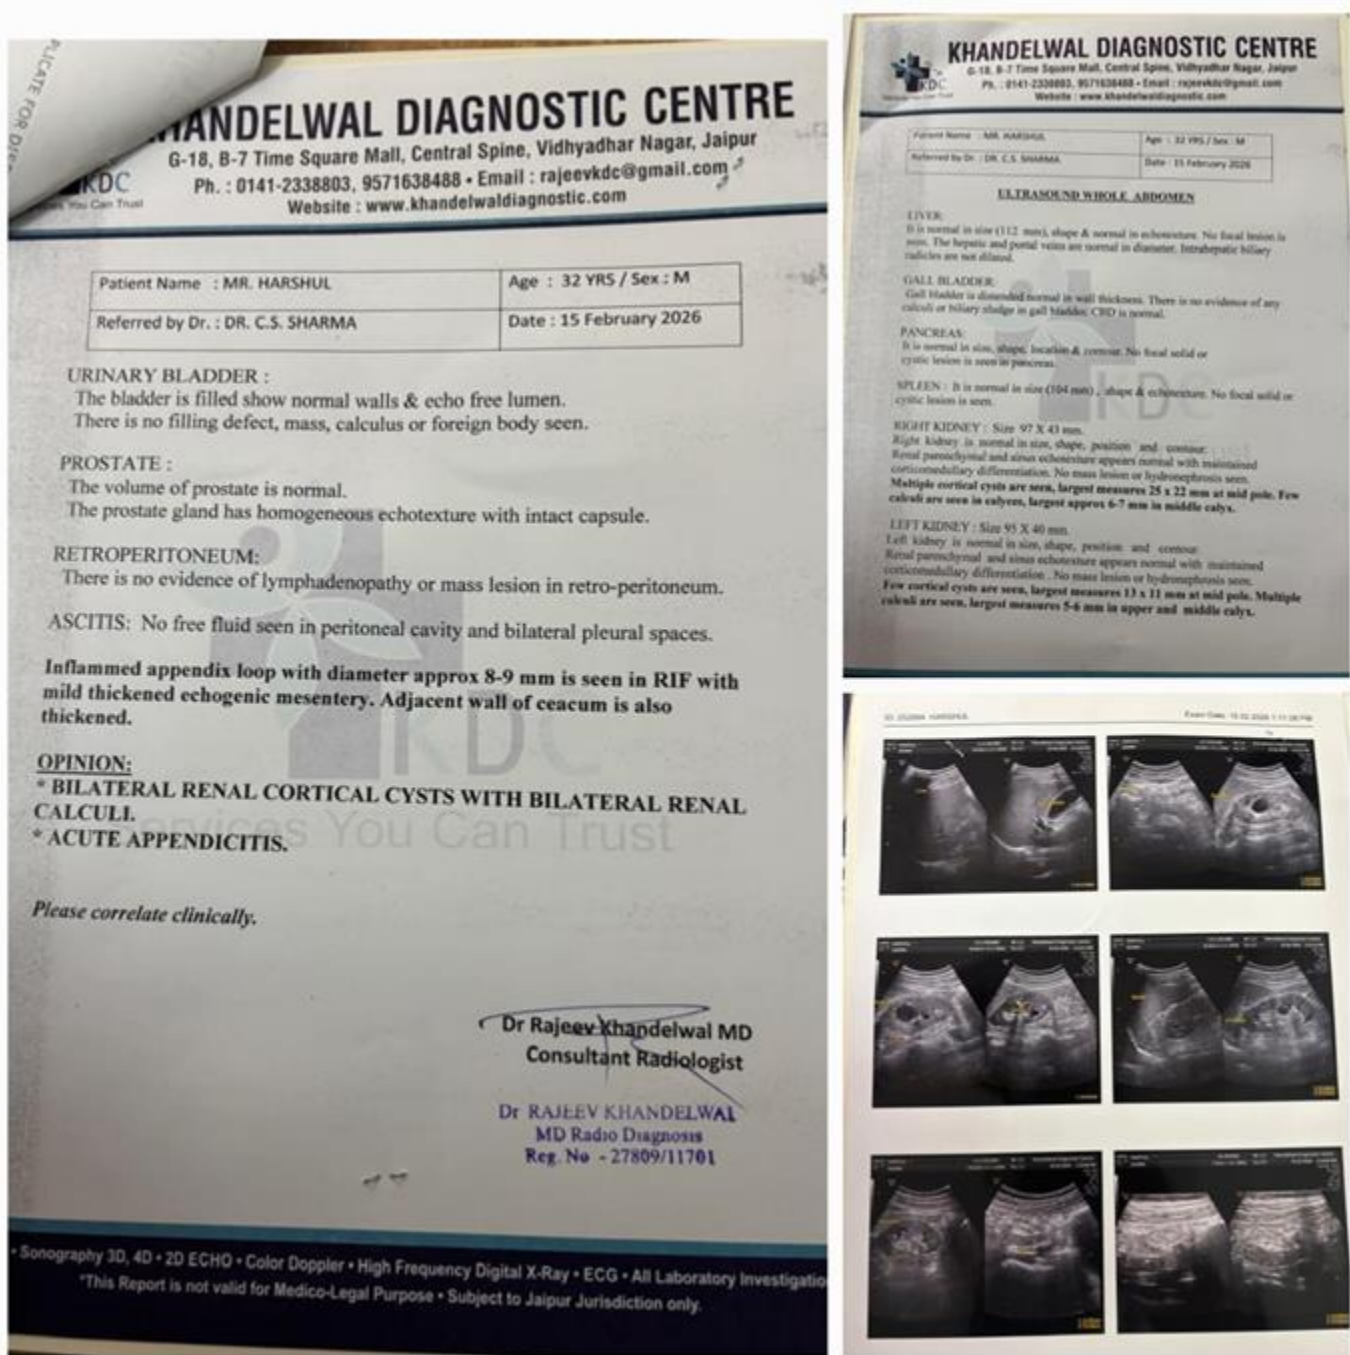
Follow-up abdominal ultrasonography (15 February 2026) showing reduced appendiceal diameter (8-9 mm) with decreased inflammatory changes.
